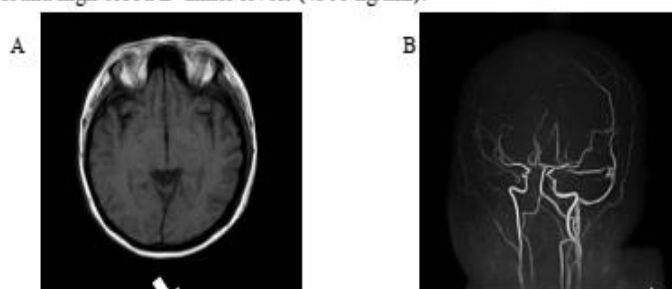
Non-Contrast Head MRI and MRA
